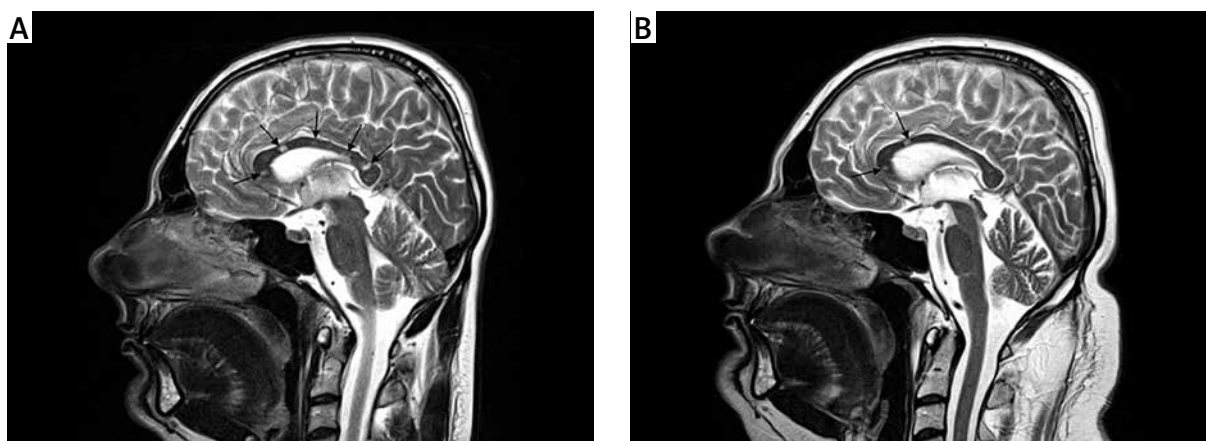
Midline sagittal unenhanced T1-weighted MRI: multiple hypointense lesions (arrowheads) in corpus callosum (A); Midline sagittal unenhanced T1-weighted MRI: decreased size and number of hypointense lesions in corpus callosum (arrowheads) (B).
